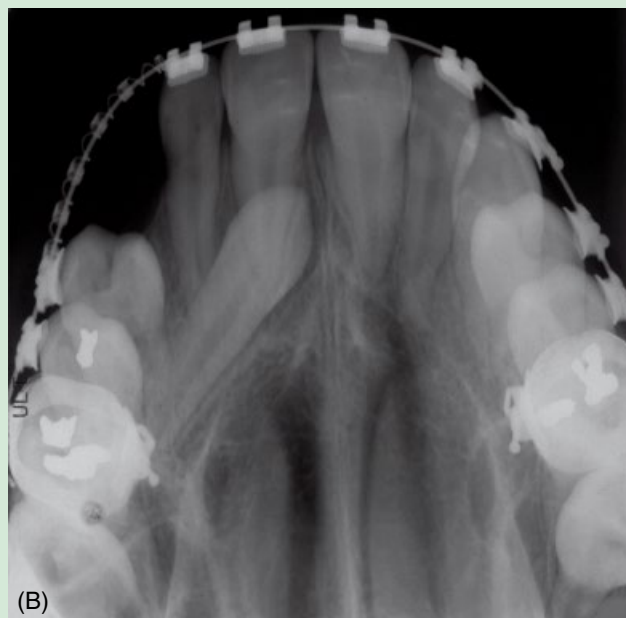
Orthodontic space preparation (A) and control X-ray before autotransplantation (B).
